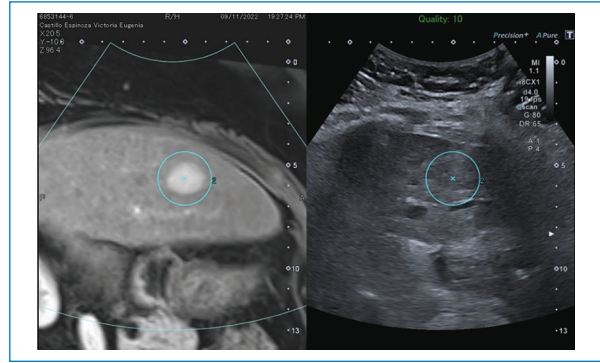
Image fusion between MRI and ultrasound prior to an HCC ablation. On the left, MRI showing an HCC. The image on the right shows the ultrasound, synchronized with the MRI, where the lesion is not visualized; however, the green ROI indicates its exact location. HCC: hepatocellular carcinoma; MRI: magnetic resonance imaging; ROI: region of interest.
